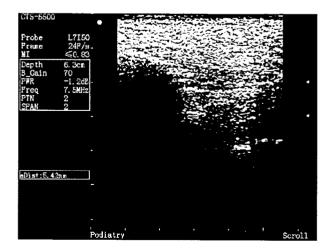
Ultrasound measuring the medial band of the plantar fascia in the sagittal plane.
